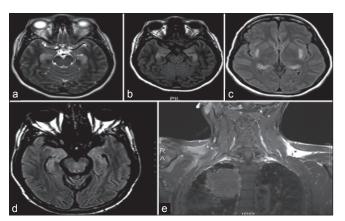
(a) Magnetic resonance imaging brain axial T2-weighted (b) axial fluid attenuated inversion recovery (FLAIR) image showing bilateral amygdala, hippocampal hyperintensity (c) axial FLAIR images showing hyperintensity in bilateral hippocampi and posterolateral aspect of bilateral putamen in patient with non paraneoplastic limbic encephalitis (d) axial FLAIR image showing bilateral amygdala, hippocampal hyperintensity (e) coronal post contrast T1w thoracic image revealing large right upper lobe lung mass in patient with paraneoplastic limbic encephalitis
